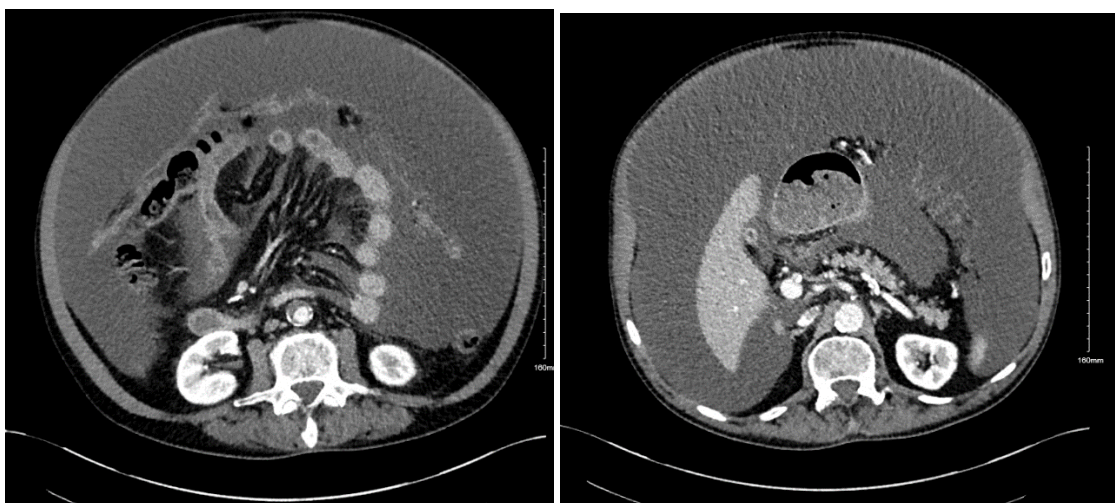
Figure A and B: Axial section of CT showing extensive ascites and peritoneal nodules
